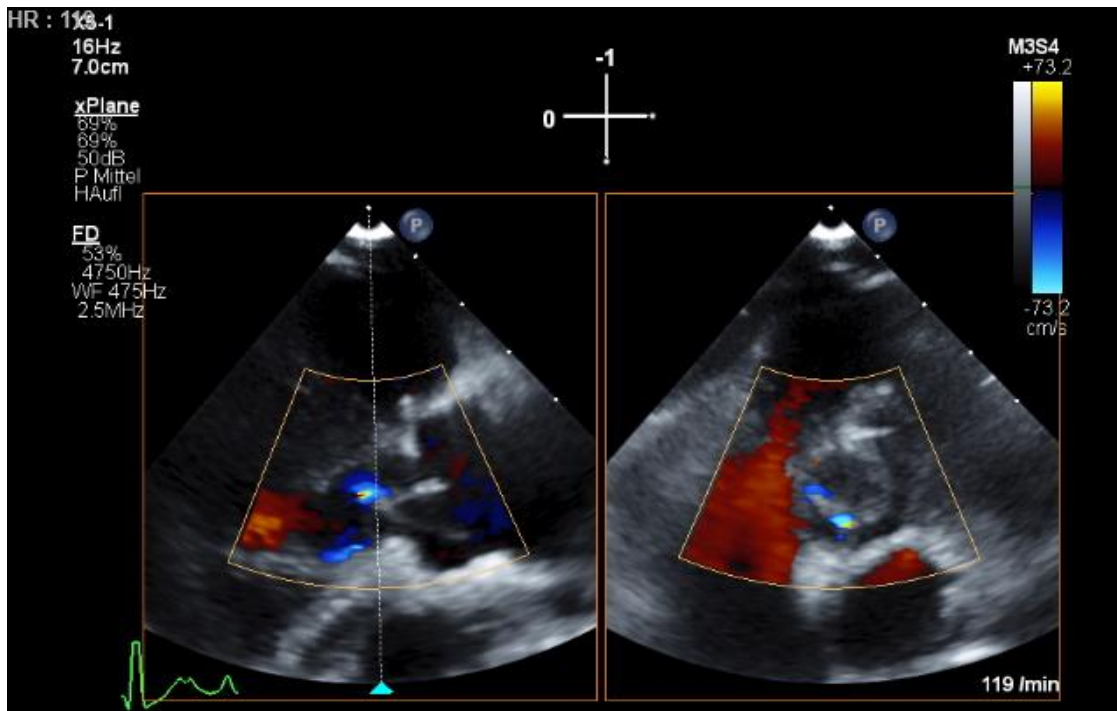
Biplane color flow transthoracic echocardiography in the follow-up
